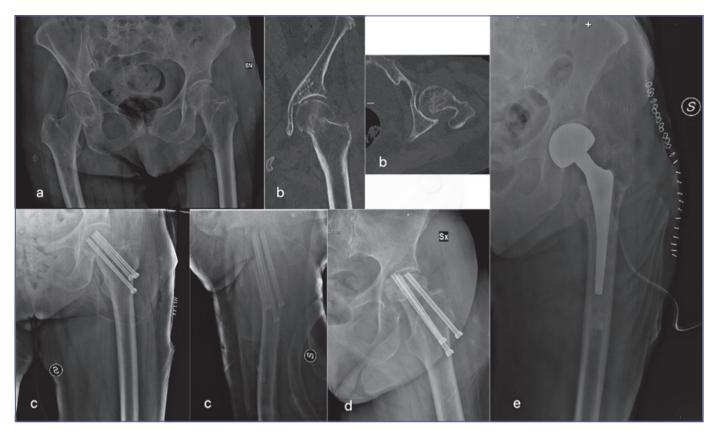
Case 1: F, 89 years old, simple fall. A) subcapital fracture of left femur; B) pre-operative CT-scan shows valgus impacted fracture with posterior tilt; C) close reduction and osteosynthesis with three cannulated screws in inverted triangular configuration at 12 h from trauma; D) At 6 months follow-up, progressive radiographic signs of symptomatic avascular necrosis; E) revision with cemented hemiarthroplasty.
